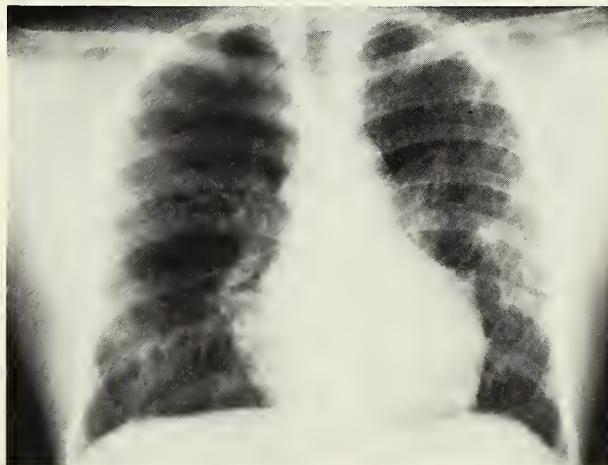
Chest x-ray 3 months after beginning of treatment reveals cavitary obliteration.
